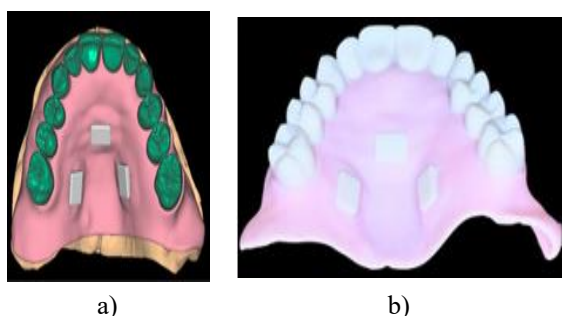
Digital plan of the radiographic guide. (a) Virtual model. (b) Radiographic guide with radiopaque markers.
